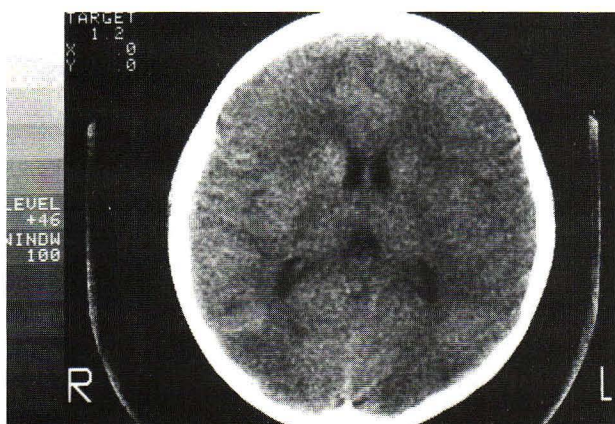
Unenhanced CT scan of case III shows decreased attenuation in parieto-occipital lobes bilaterally.
